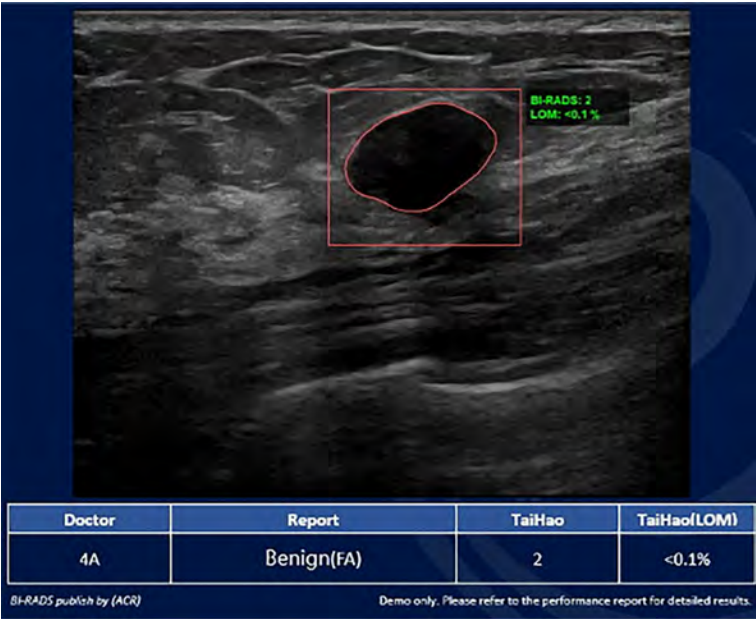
Artificial intelligence/radiologist discrepancy. Breast Ultrasound Computer-Aided Diagnosis (BU-CAD) interface with the US image of the outlined lesion. This mass was categorized as BI-RADS 2, <0.1% likelihood of malignancy (LOM). At the bottom, the radiologist's assignment of BI-RADS 4A and TaiHao's BU-CAD assignment of BI-RADS 2 are displayed. This mass demonstrated benign pathology via fine needle aspiration. Image courtesy of TaiHao Medical Inc.
